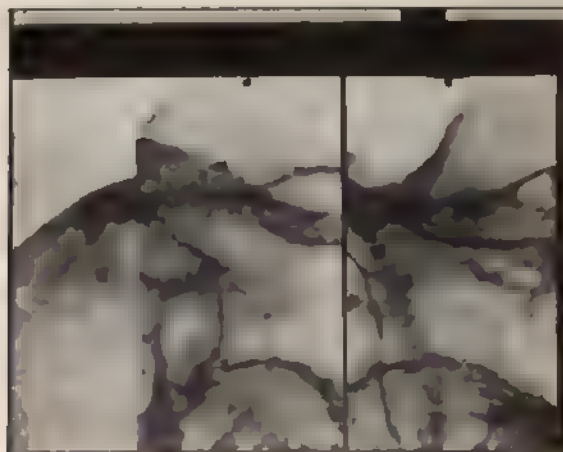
Radiograph of foreign body in eye (three fourths actual size (Sweet))
